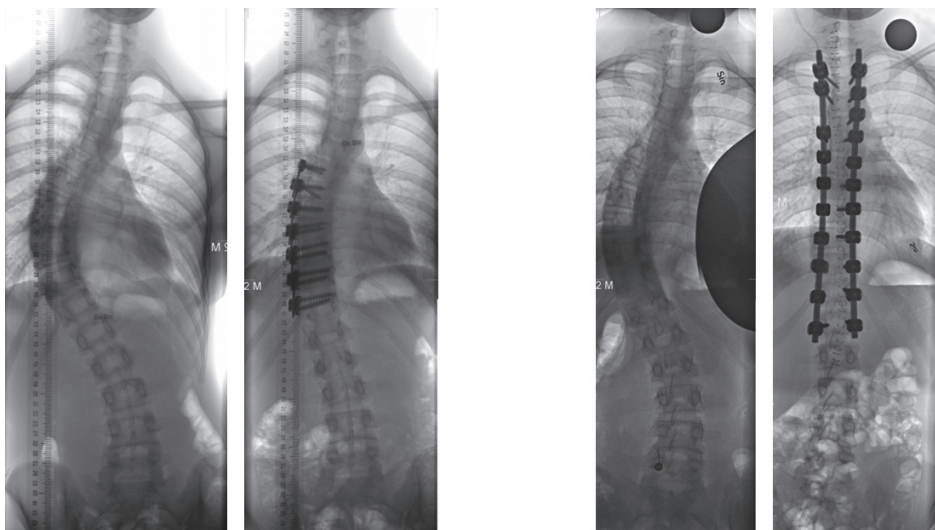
Pre- and postoperative radiographs of two Lenke curve type 1 patients, that were operated with an anterior or posterior approach.
